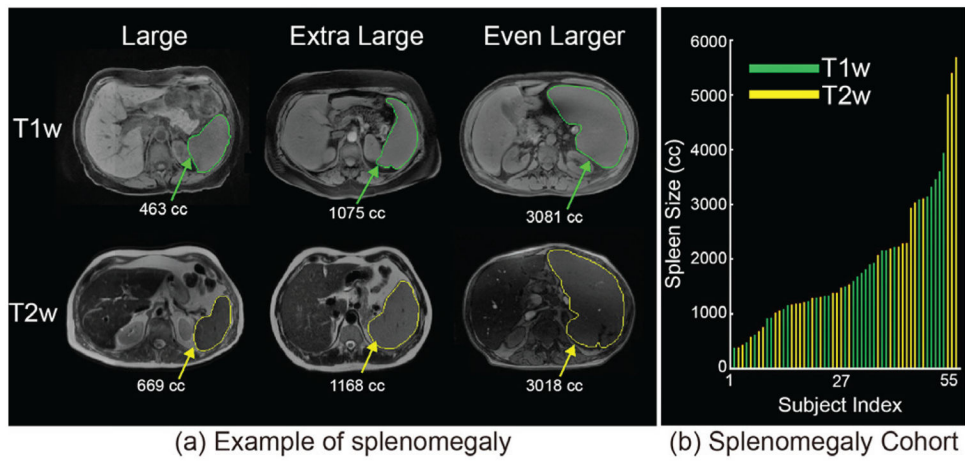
(a) presents heterogeneous sequences in clinical acquired abdominal MRI as well as the examples of splenomegaly spleens on MRI. (b) shows the spleen size and sequence type of all 55 MRI.
